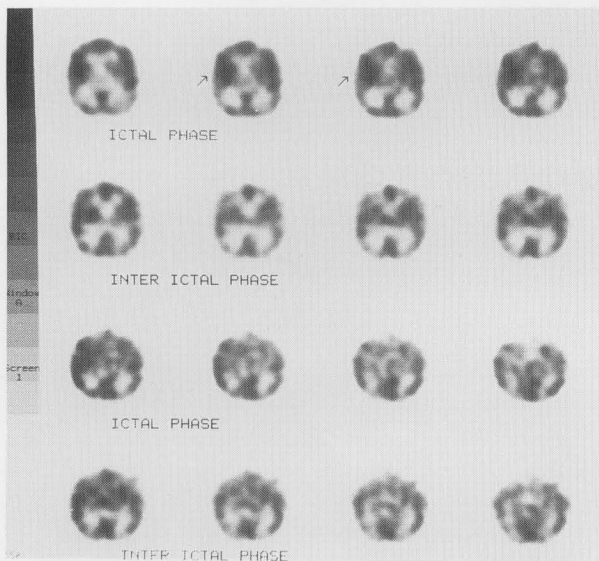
The ictal and interictal Tc-99m HMPAO brain SPECT transaxial slices of a reading epileptic patient. The hyperperfusion of right superior temporal region in ictal phase (arrow) whereas the normal perfusion was shown at the same region in the interictal phase.
